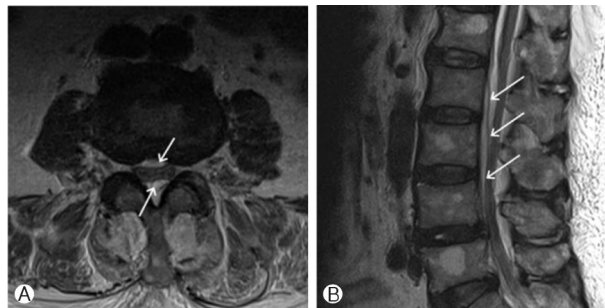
67-year-old woman with epidural abscess. T2-weighted axial (A) and sagittal (B) MR images showing anterior and posterior epidural abscesses through L-spines causing thecal sac compression (arrows).
